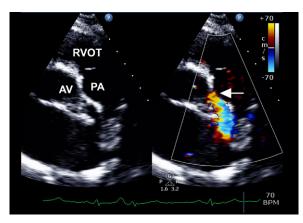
Transthoracic echocardiogram (in modified parasternal short-axis view and color-flow Doppler mode) shows anomalous flow arising from the pulmonary artery (PA) (arrow).
